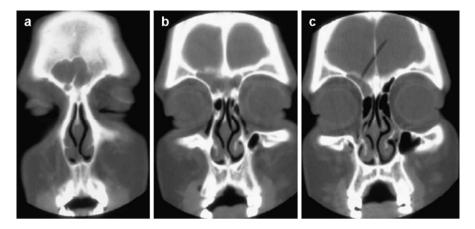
A 16-year-old girl complaining of frontal headaches for over 1 year was diagnosed with migraine headaches. (a, b) On CT scan, the frontal sinuses are completely opacified. (c) Prominent agger nasi cells with obstruction of the right frontal recess
